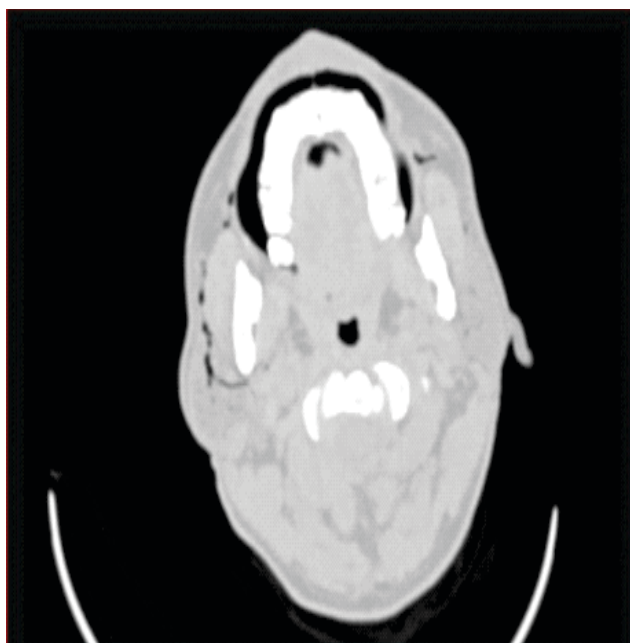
Axial and Coronal CT scan of face and neck : Multiple air foci are seen in bilateral stenson's ducts and parotid glands.
